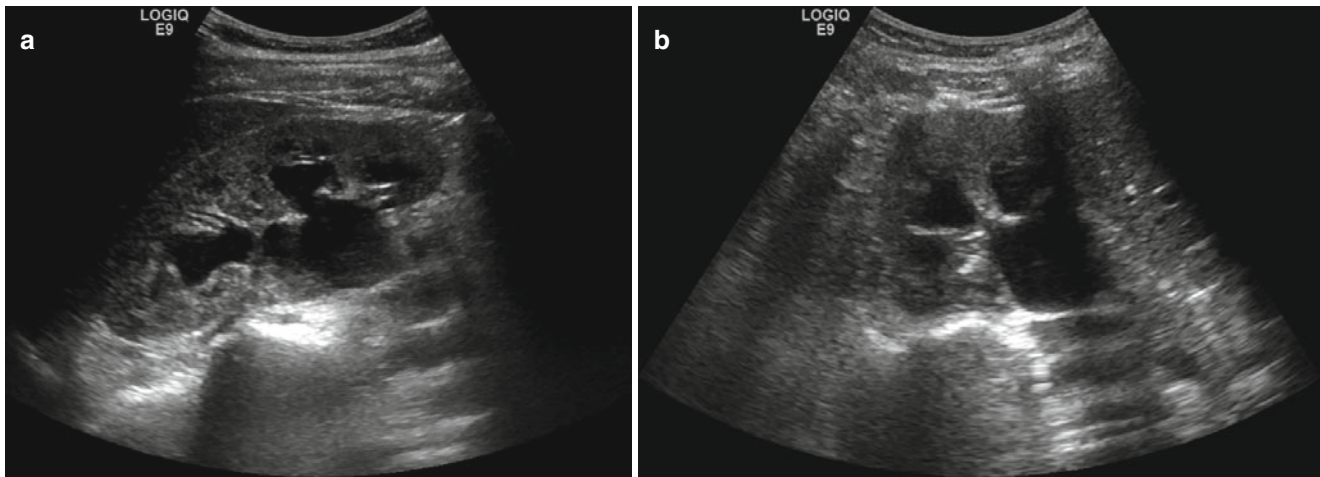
Hydronephrosis. Sagittal (a) and transverse (b) sonographic images of the right kidney. The renal collecting system is symmetrically dilated, including dilatation of the renal calyces and central collecting system
